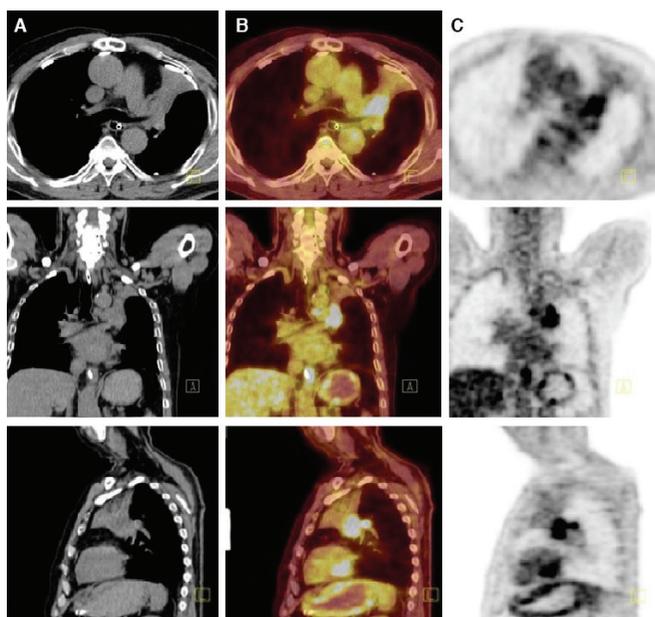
Axial, coronal, and sagittal CT images (A), fused PET/CT images (B) and PET images (C) of the patient with small cell lung carcinoma. The tumor size could not clearly be assessed on CT images. The fused PET/CT images enables differentiation of tumor and atelectasis areas due to intense FDG uptake of the tumor area [tumor maximum standardized uptake value (SUV_{max}): 10, atelectasis SUV_{max} : 3.7], thus, the tumor size has been correctly calculated
